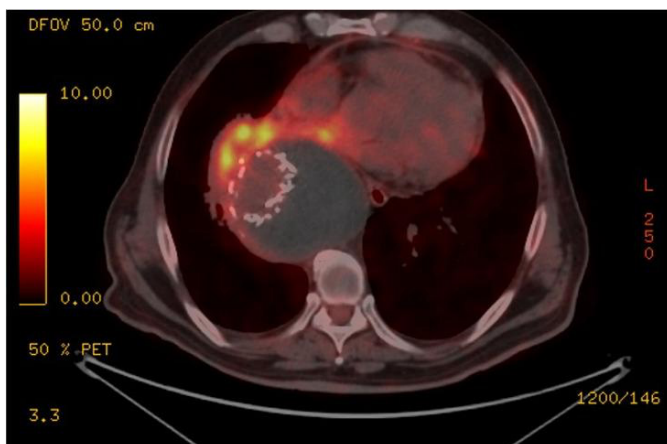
The abnormal methabolic activities in the anterior wall of the aort in PET/CT
